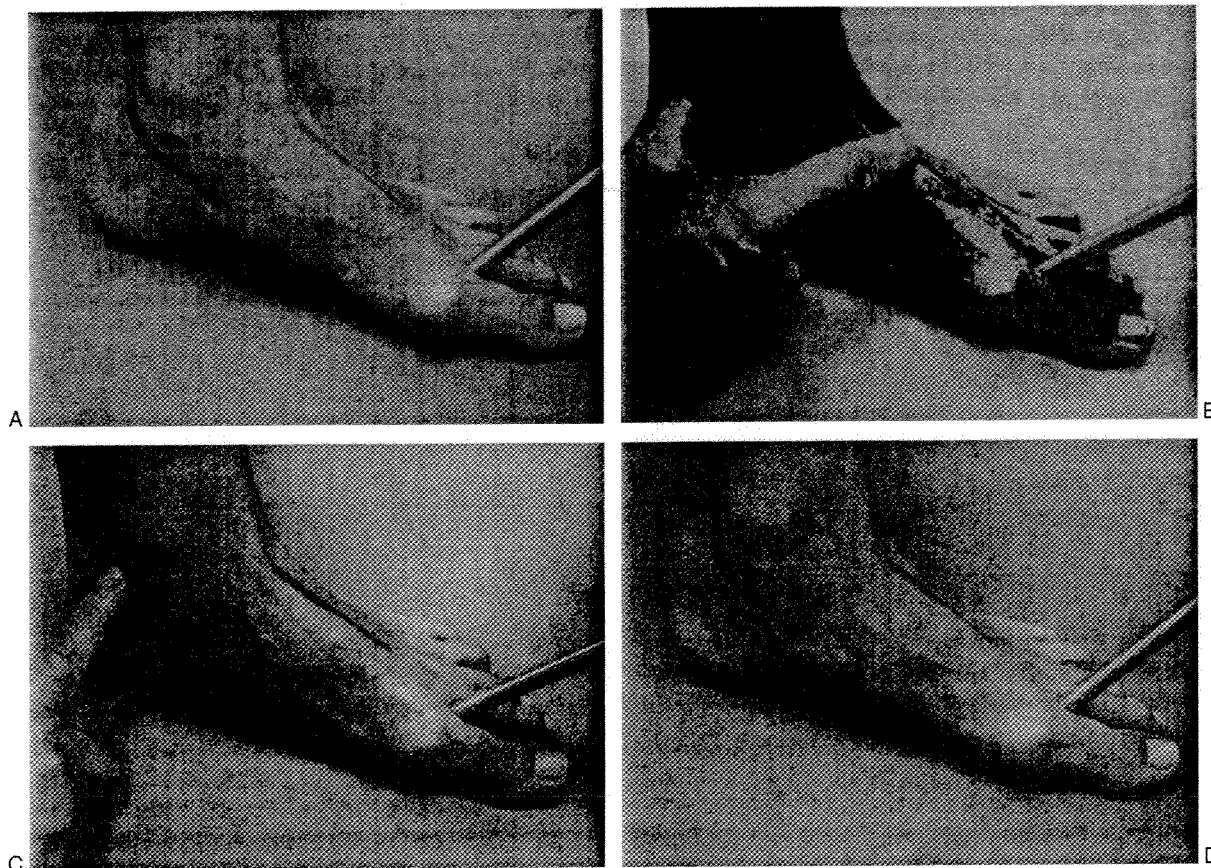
(A) A handheld Doppler is used to locate the first dorsal metatarsal artery. (B) The posterior tibial artery (PT) and the dorsalis pedis artery (DP) pulses are simultaneously palpated and compressed. A persistent signal indicates collateral flow through the peroneal artery. (C) If the signal is extinguished, pressure on the DP artery is released. Return of a signal indicates adequate DP flow. (D) If releasing pressure on the DP does not result in return of signal, the PT is released. Resumption of a distal signal under these conditions indicates that the distal foot is dependent on the PT for perfusion.
